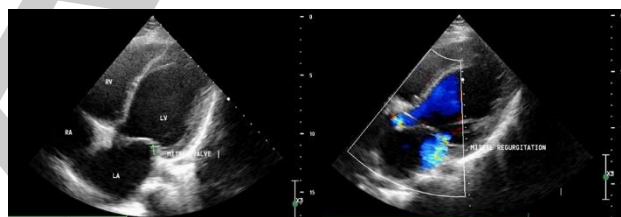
Echocardiography reveals dilated four chambers and a dilated cardiomyopathy with an ejection fraction of 30%, accompanied by mitral and tricuspid regurgitation
